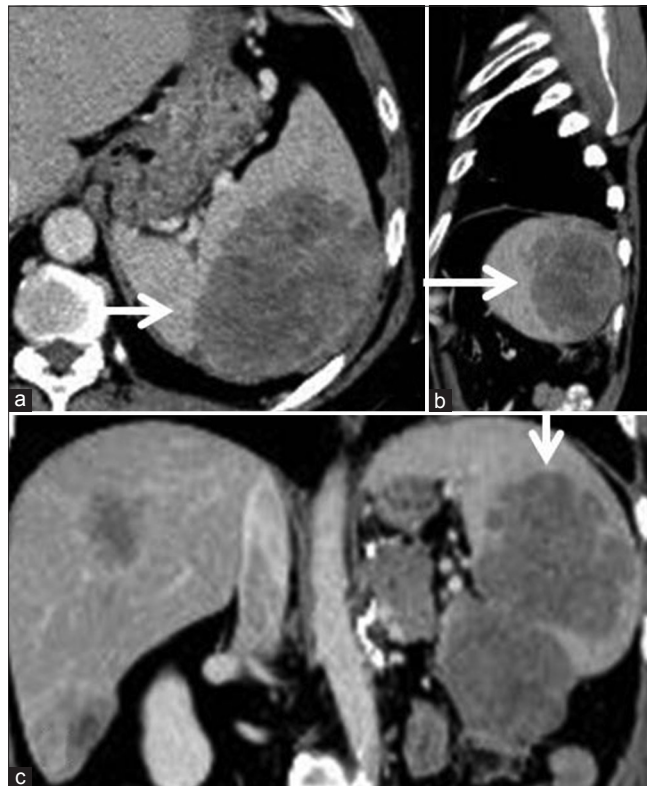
Contrast enhanced computed tomography (CECT) scan; axial (a) sagittal (b) and coronal (c) images reveal a large hypodense inhomogeneously enhancing mass (arrow) in the spleen. In addition to the splenic metastasis, metastatic lesions are also seen in the liver with recurrence in the left renal bed (c)
